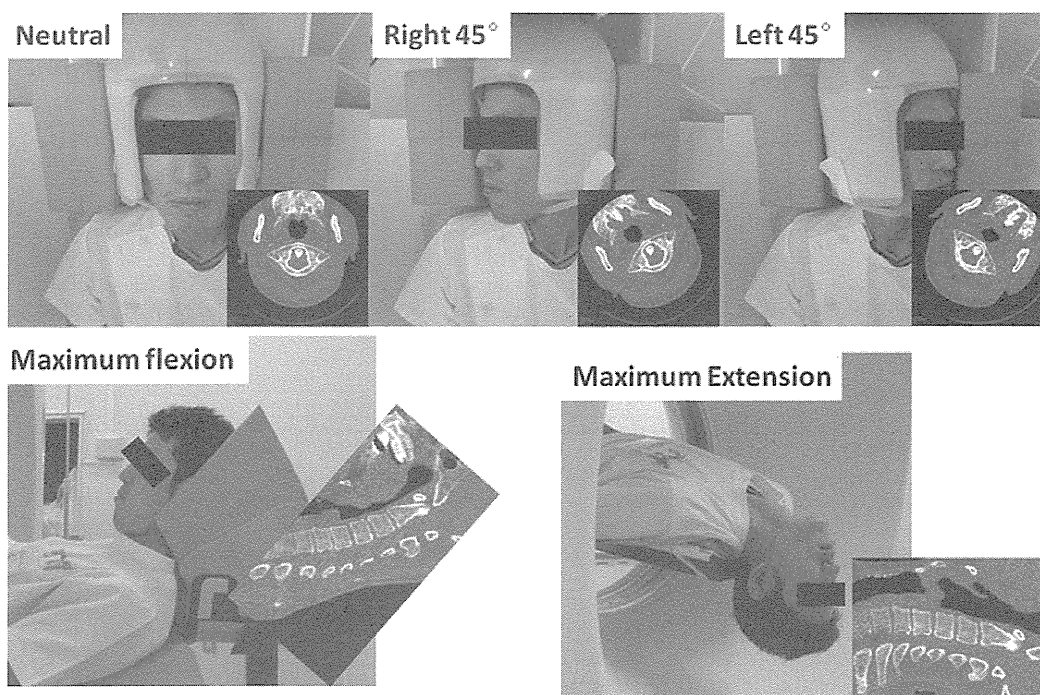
Photographs and representative scans showing the 5 positions used for CT. Two types of supportive devices were used: one designed to facilitate production of the same 45° head rotation, and one to help maintain maximum flexion during scanning.
